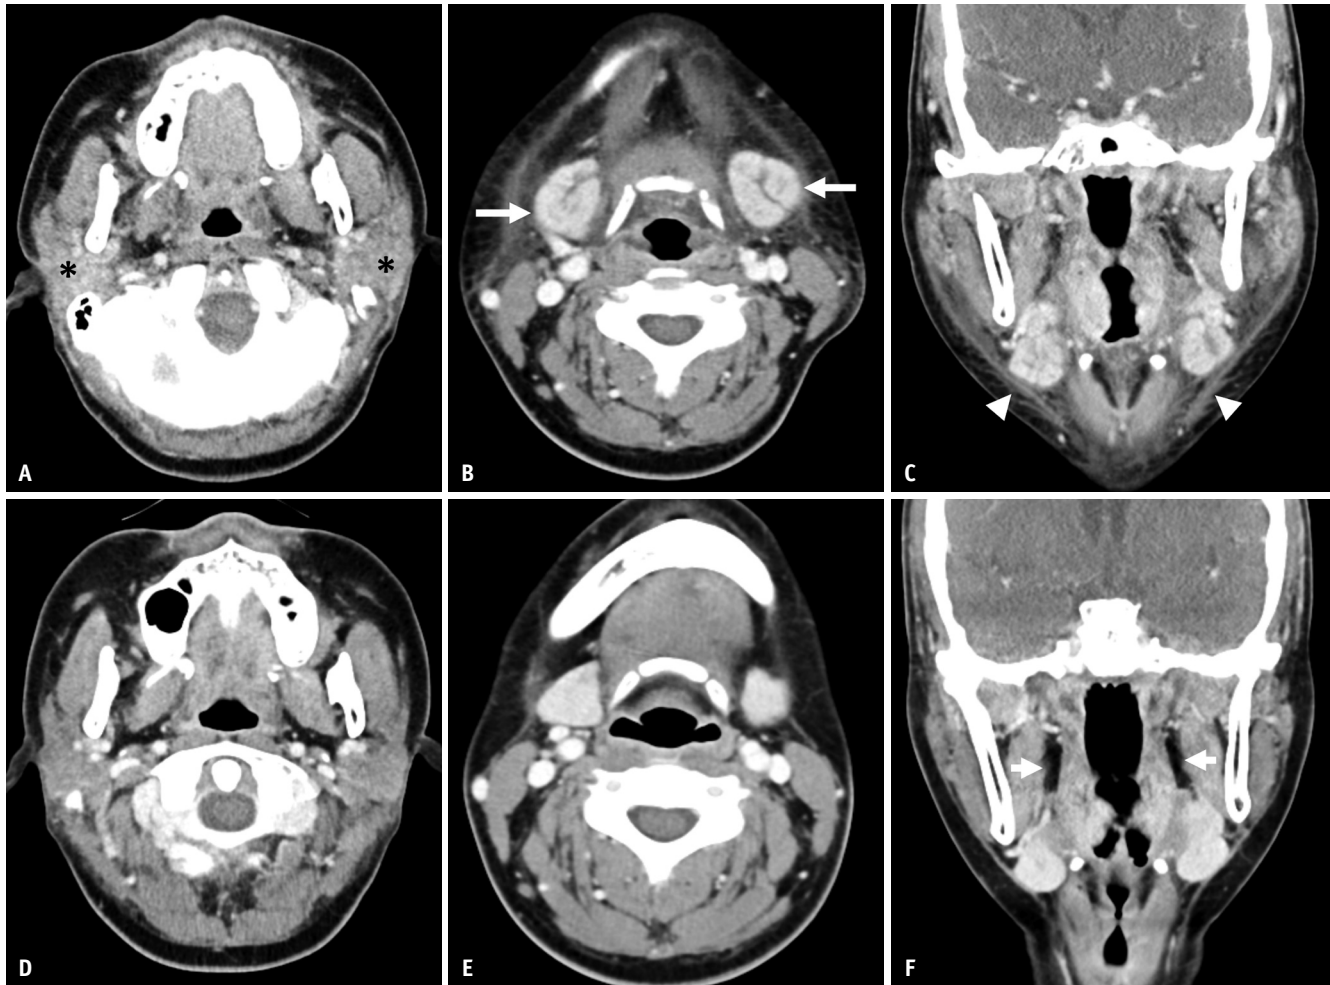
An exemplar case of a 20-year-old female with acute lymphoblastic leukemia treated with CAR-T cell infusion therapy. A-C: Four days after CAR-T cell infusion therapy, diffuse swelling in both the parotid (asterisks, A)/submandibular glands (arrows, B), pharynx, parapharyngeal fat, and supraglottic larynx with subcutaneous and deep cervical fat infiltration can be observed. Thickening and infiltration of the platysma muscles can also be seen (arrowheads, C). D-F: One week after dexamethasone treatment for local cytokine-release syndrome, the diffuse swelling in both the parotid/submandibular glands, entire pharynx, parapharyngeal fat (arrows, F), and supraglottic larynx is completely resolved on axial and coronal neck CT with enhancement. CAR-T = chimeric antigen receptor T
